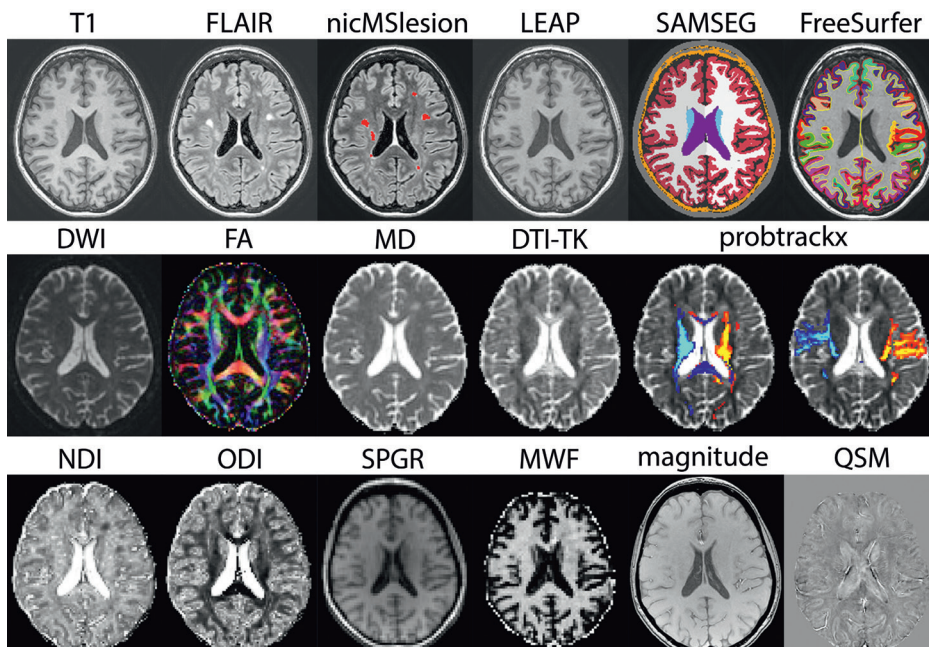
Overview of MR imaging analysis.
